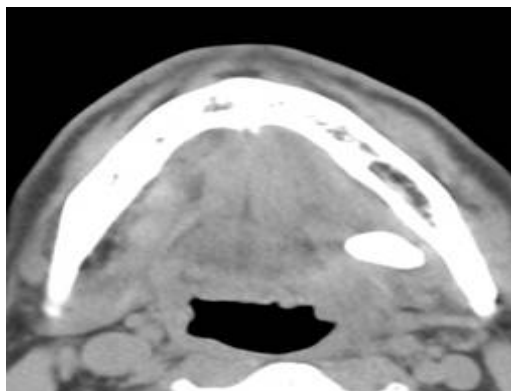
CT image of sialolithiasis of left Wharton's duct. (1.5cm sized)
